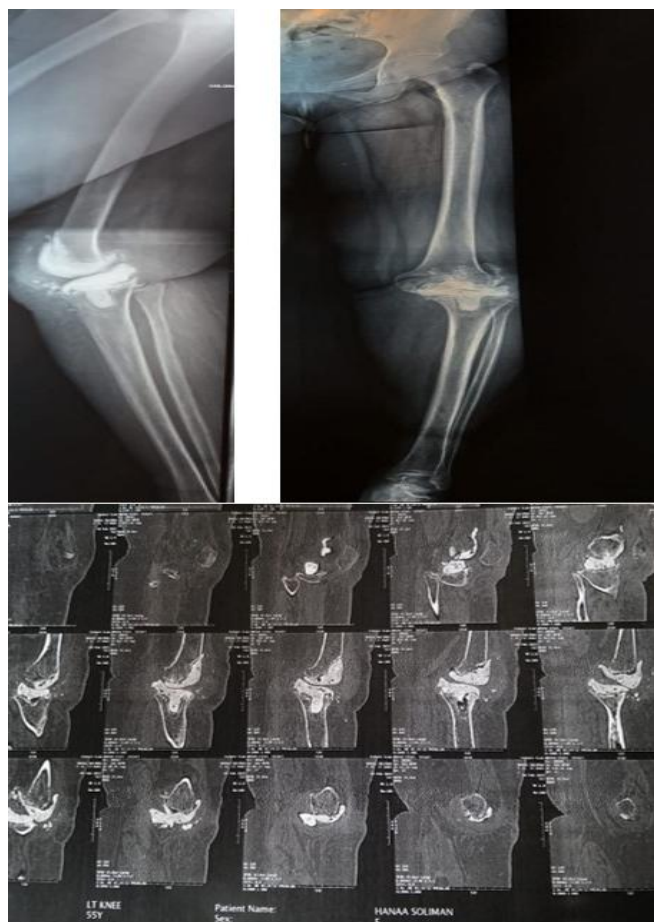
Preoperative x ray & CT showing knee cement spacer with tibial defect type-III
